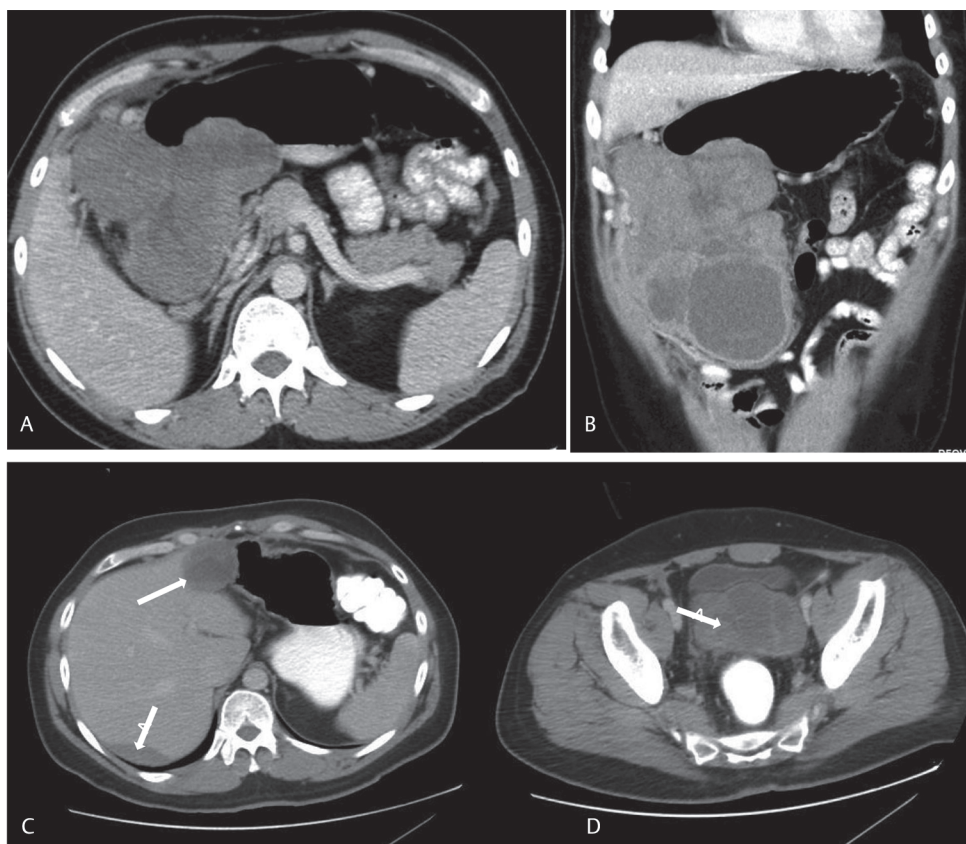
(A) Axial and (B) coronal contrast-enhanced CT images showing markedly necrotic ascending colonic gastrointestinal stromal tumor (GIST) with lobulated and slightly irregular contour in right hypochondrium and lumbar region, displacing the bowel loops medially and with infiltration into stomach. High risk. Mitotic index (MI) > 5/50HPF. Size 15.8 cm. (C) axial upper abdomen and (D) axial pelvic contrast-enhanced CT images of follow-up scan, 1-year postsurgery showing recurrence at the postoperative site near the stomach as well as perihepatic and pelvic deposits (white arrows).
